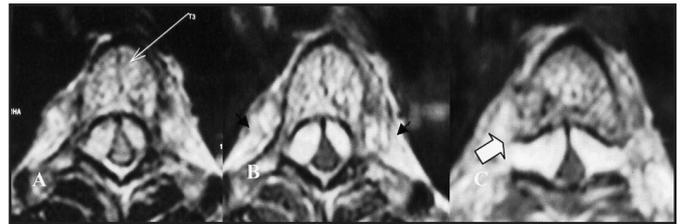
Axial T2WI MRI plain (A) and with gadolinium (B) at pedicle level of T3 which demonstrate homogenous and intensely enhancing epidural mass causing thoracic cord compression, with mottled hyperintense signals within T3 vertebral body (white arrow) and present of bilateral paravertebral mass (black arrow). (C) Axial T2WI MRI with gadolinium at level of T3/4 intervertebral foramen reveal continuation of epidural mass bilaterally with paravertebral mass through the neural foramina (block arrow).
